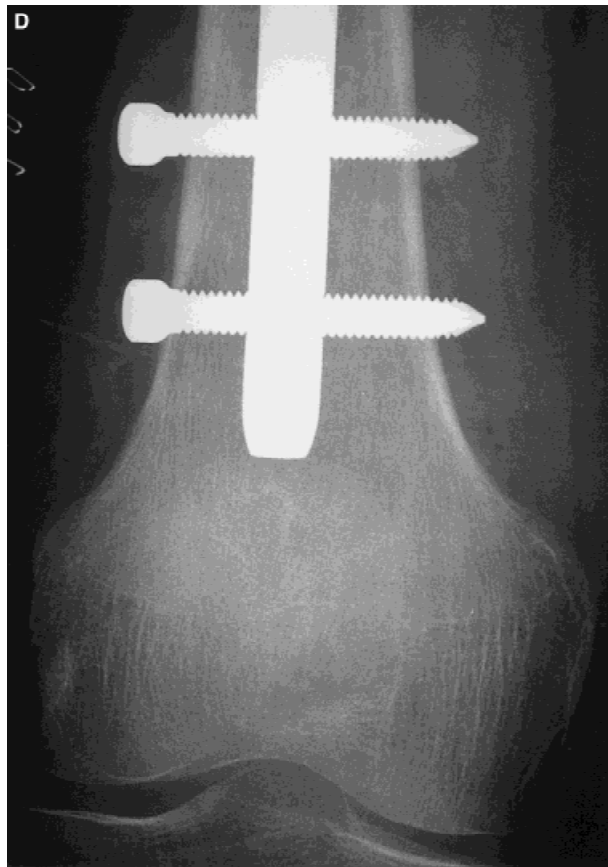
Anterior cortical penetration. Anteroposterior radiographs of (A) hip and (B) proximal femur showing impending pathologic femur fracture in patient with metastatic prostate carcinoma. C: Postoperative anteroposterior radiograph of the hip following placement of the long Gamma nail. D: Postoperative anteroposterior radiograph of the distal end of the femur showing apparent acceptable position of two distal interlocking screws. However, review of the lateral radiograph (E) shows that the distal tip of the nail has partially penetrated the anterior cortex. Despite this finding, the patient was allowed immediate full weight bearing postoperatively and progressed to excellent pain relief without loss of fixation or fracture.
